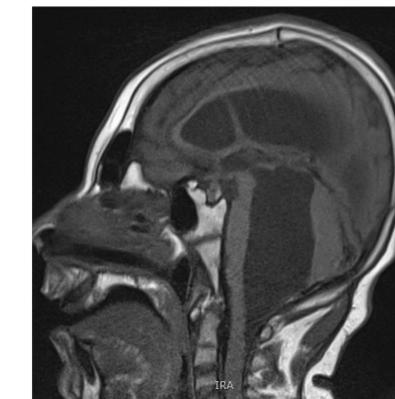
sagittal MRI shows cystic dilation of ventricles, particularly the 4th ventricle causing mass effect upon the brainstem and cerebellum, and schizencephaly.
